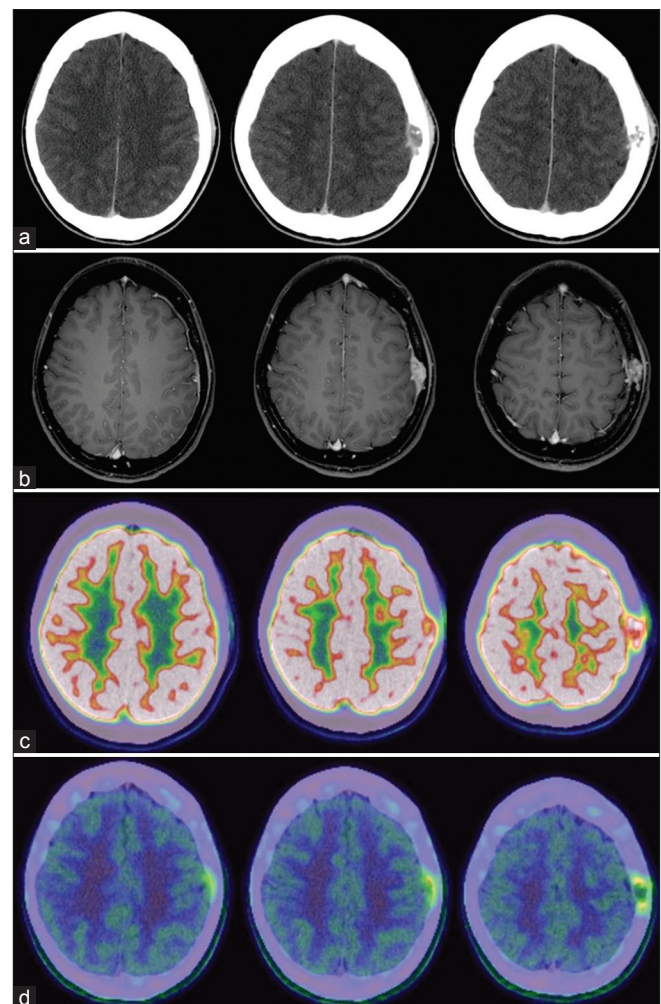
(a) A preoperative enhanced computed tomography revealed a bone defective part and an enhanced mass. (b) A preoperative Gadolinium enhanced T1-weighted image demonstrates the presence of a mass, which is enhanced with dural surface and subgaleal tissue. (c) Fluorodeoxyglucose positron emission tomography shows a high uptake in the osteolytic lesion observed on the left. (d) Methionine positron emission tomography demonstrates a high uptake in the marginal zone of the osteolytic lesion and dura mater, and a low uptake in the central zone of the osteolytic lesion
